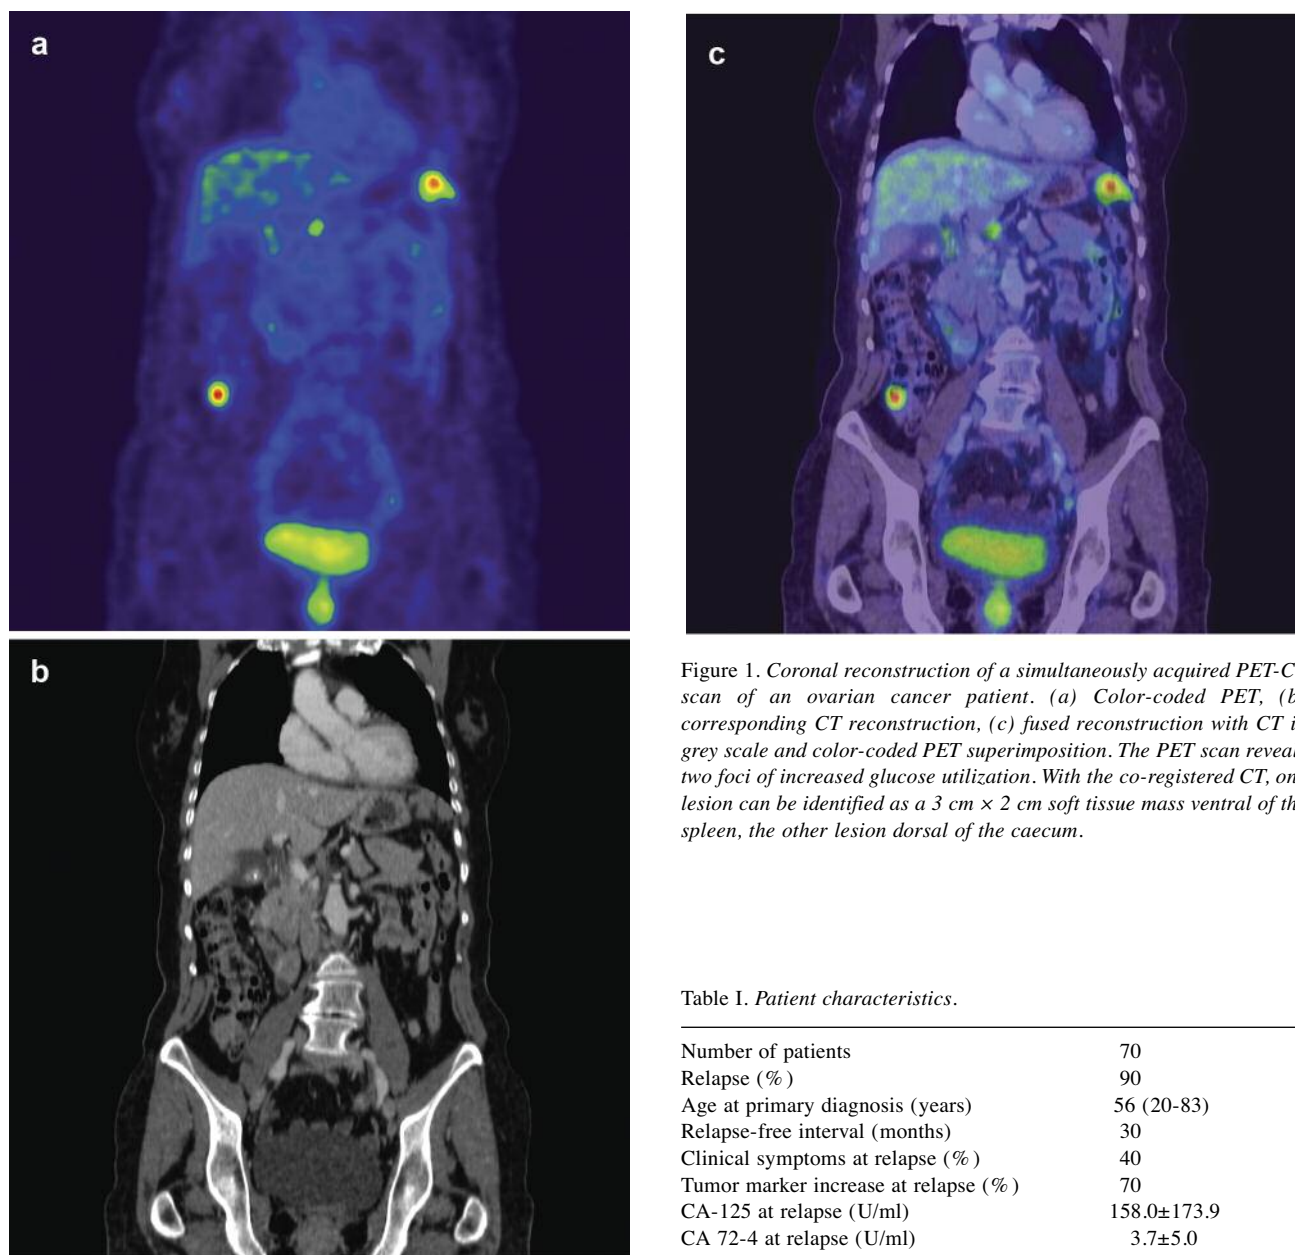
Coronal reconstruction of a simultaneously acquired PET-CT scan of an ovarian cancer patient. (a) Color-coded PET, (b) corresponding CT reconstruction, (c) fused reconstruction with CT in grey scale and color-coded PET superimposition. The PET scan reveals two foci of increased glucose utilization. With the co-registered CT, one lesion can be identified as a 3 cm × 2 cm soft tissue mass ventral of the spleen, the other lesion dorsal of the caecum.
